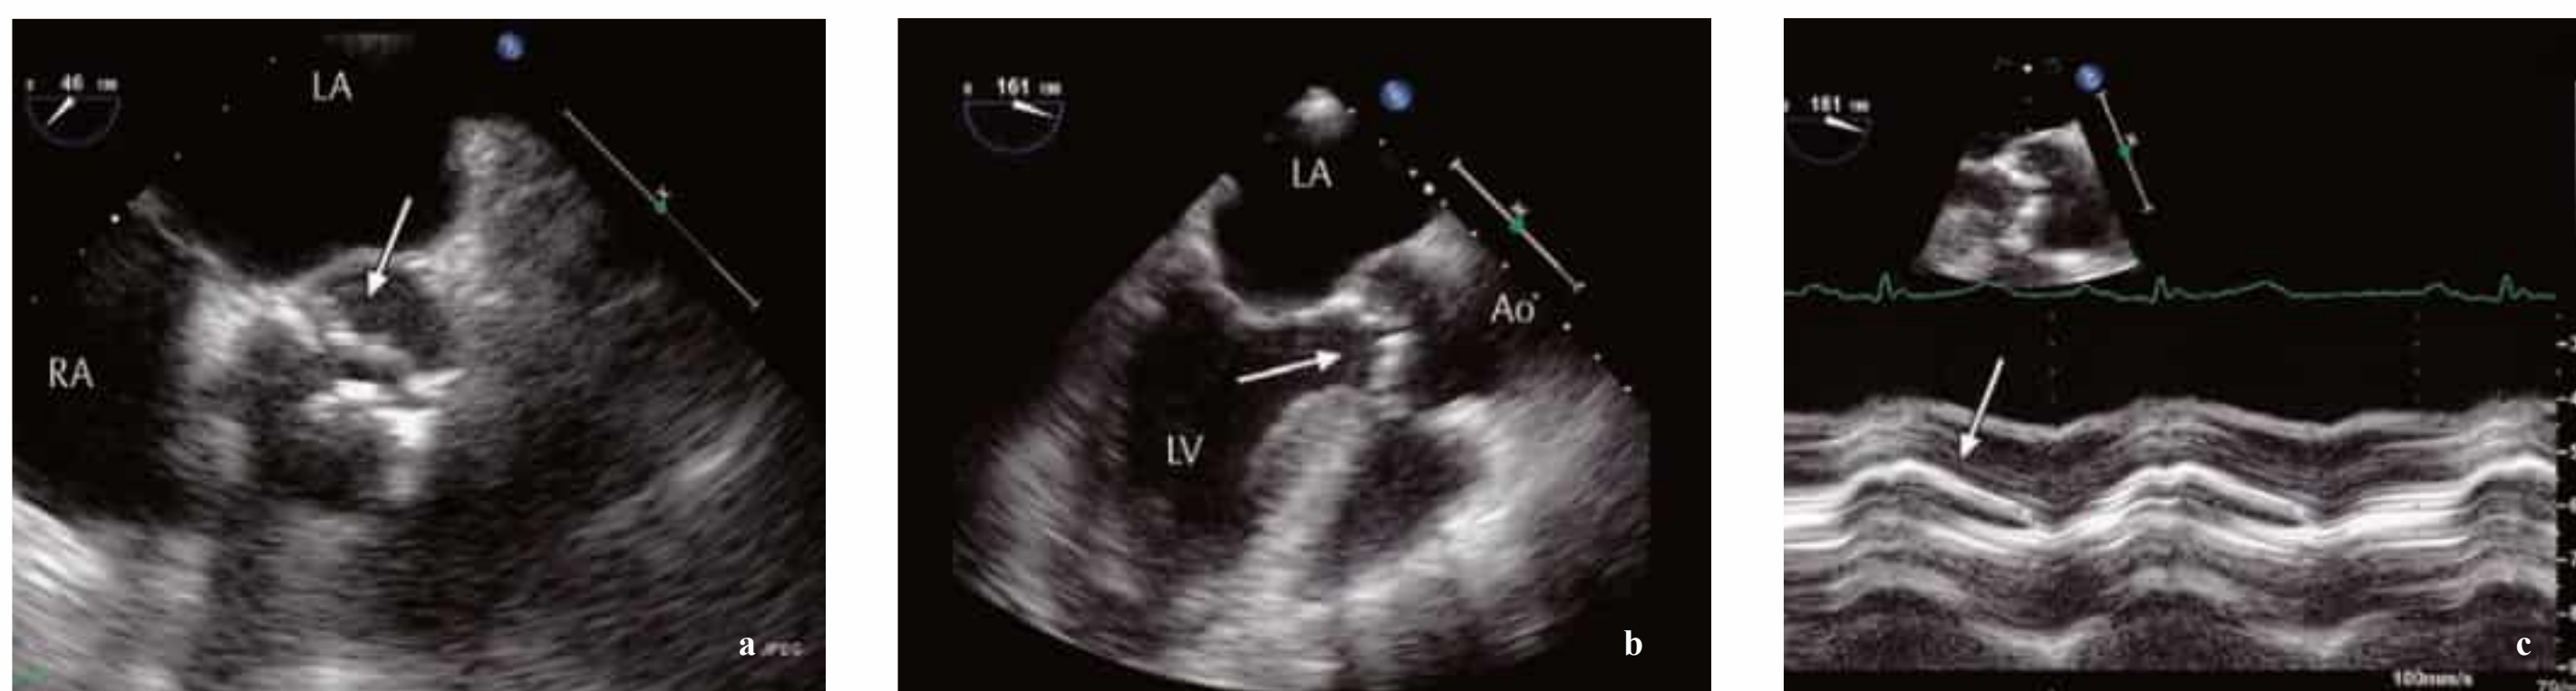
a–c Aortic valve stenosis imaged by transesophageal echocardiography.
